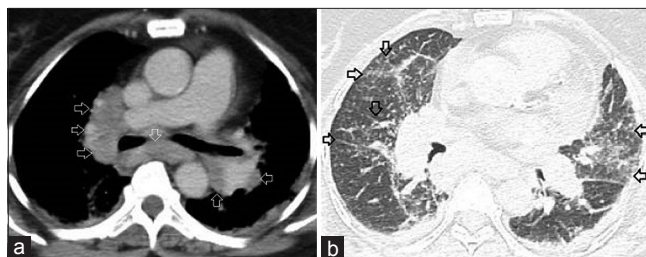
(a) Axial contrast enhanced CT chest image showing multiple bilateral enlarged subcarinal and hilar nodes with homogeneous enhancement and no necrosis (arrows) and (b) Axial HRCT chest images showing reticulonodular interstitial thickening with fissural nodules (arrows)
